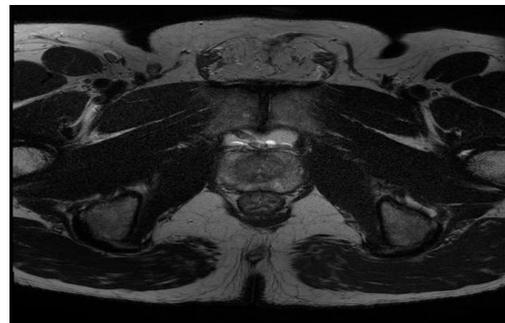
Example multiparametric MRI slices of the same prostate gland, using T2w and diffusion-weighted imaging (DWI). Each modality provides different information about the prostate gland to aid in the clinical decision support process.
